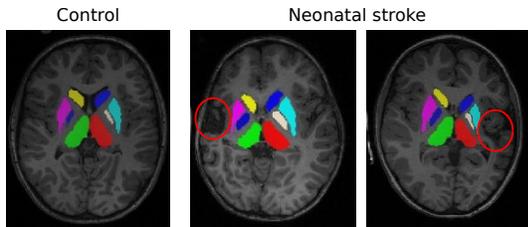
NAIS detection: example of MRI of both classes. Left: control brain with a good symmetry between hemispheres. Right: injured brains (the lesion is circled in red).
